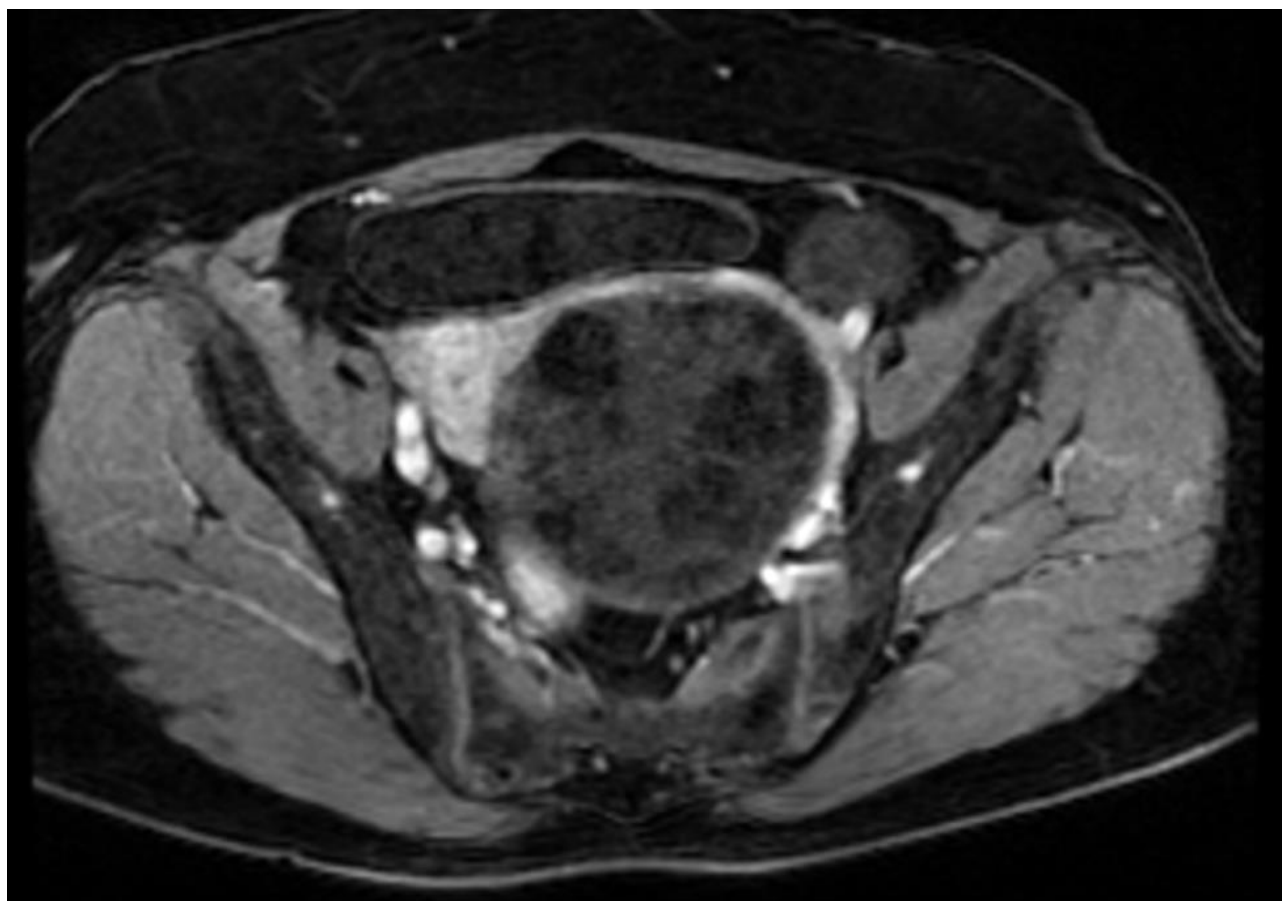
Contrast-enhanced T1-weighted fat-suppressed MRI showing the pelvic masses, with no post-contrast enhancement.
